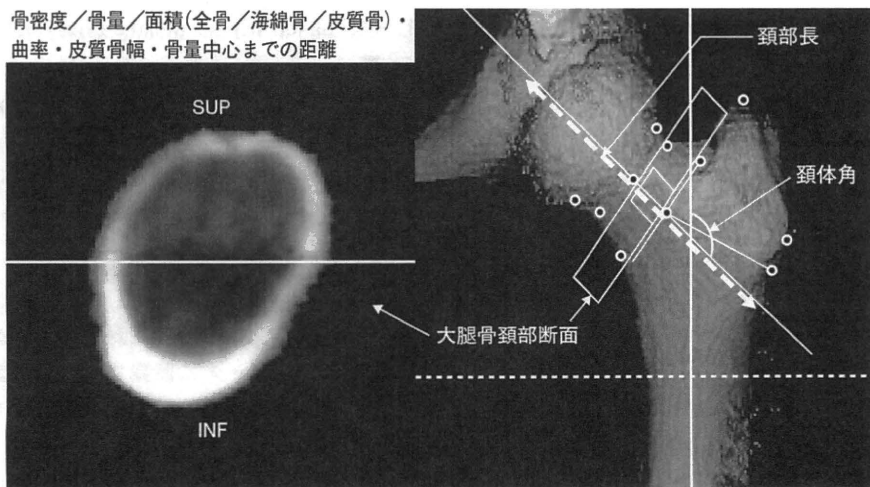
CT-based HSA で得られる主なパラメーター
